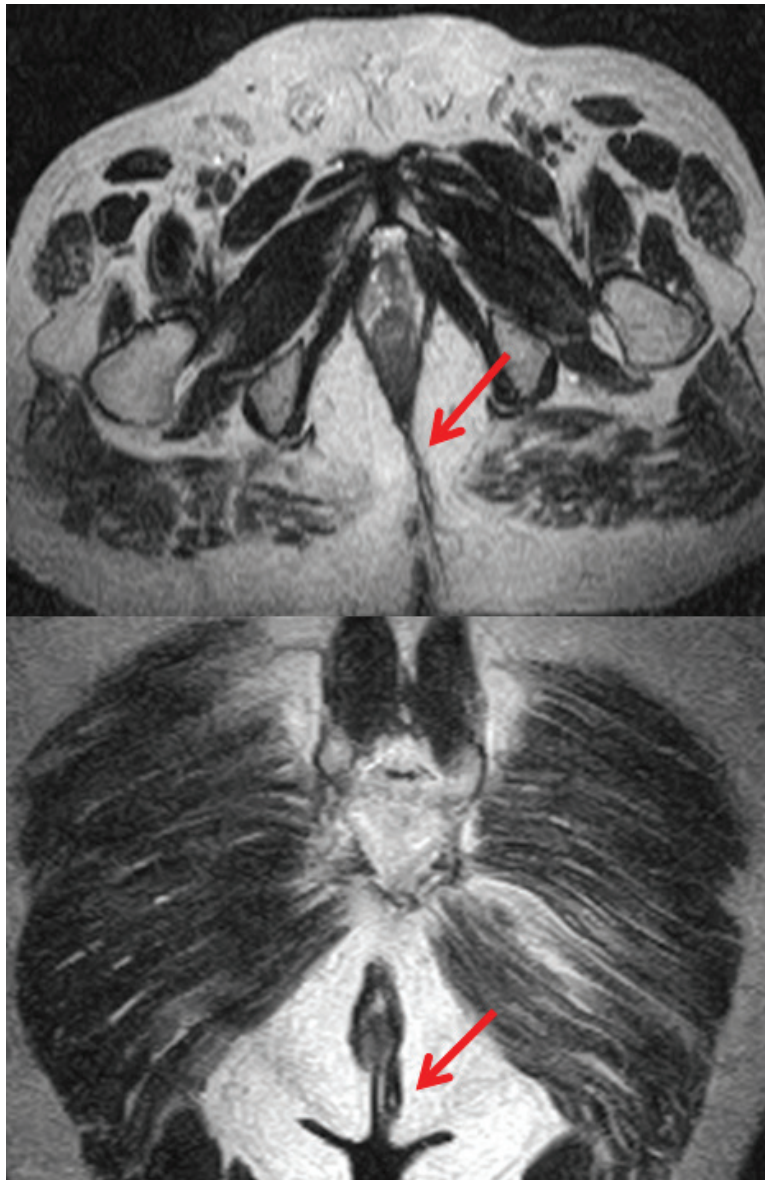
a,b: Axial (a) T2 weighted MRI showed linear posterior fistula (arrow) with external opening at 5'o clock and internal opening at 6'o clock position. Coronal (b) T2 weighted MRI showed linear posterior fistula (arrow) with external opening and internal opening at 5'o clock. Goodsall's rule does not hold good in these cases.
